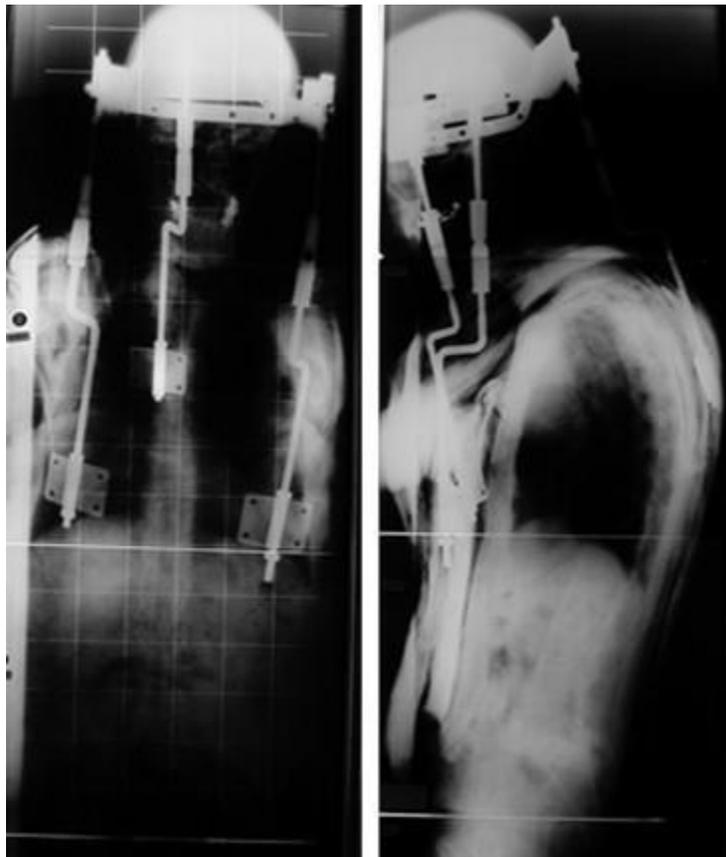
AP and lateral radiographs of a patient non-operatively treated using a halo vest. Note that the anterior turnbuckles have to rely on the chest because of the kyphosis.
